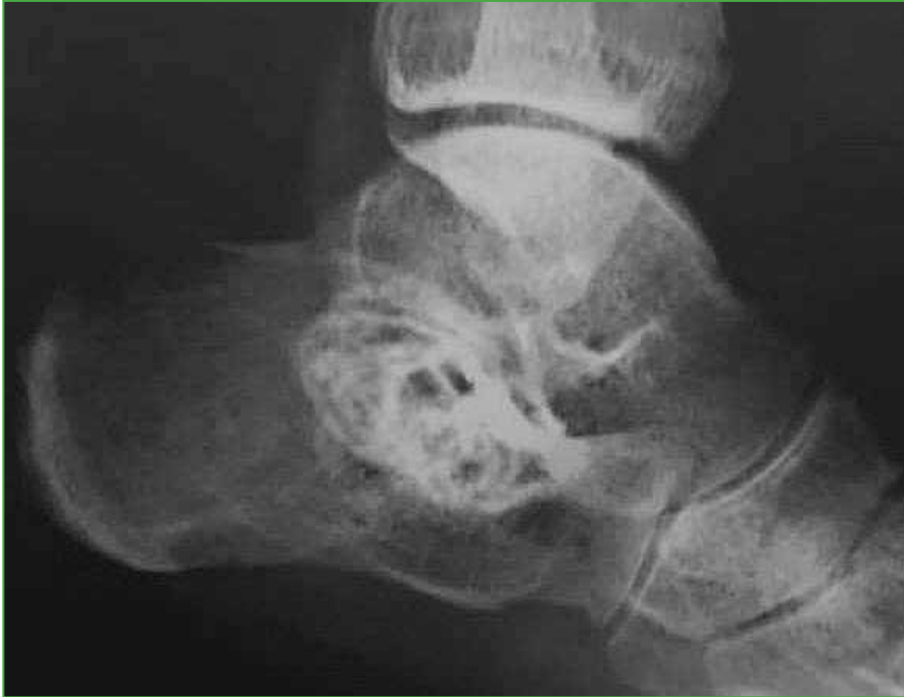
Lateral radiograph of the internal side of the foot, four months after the procedure.
